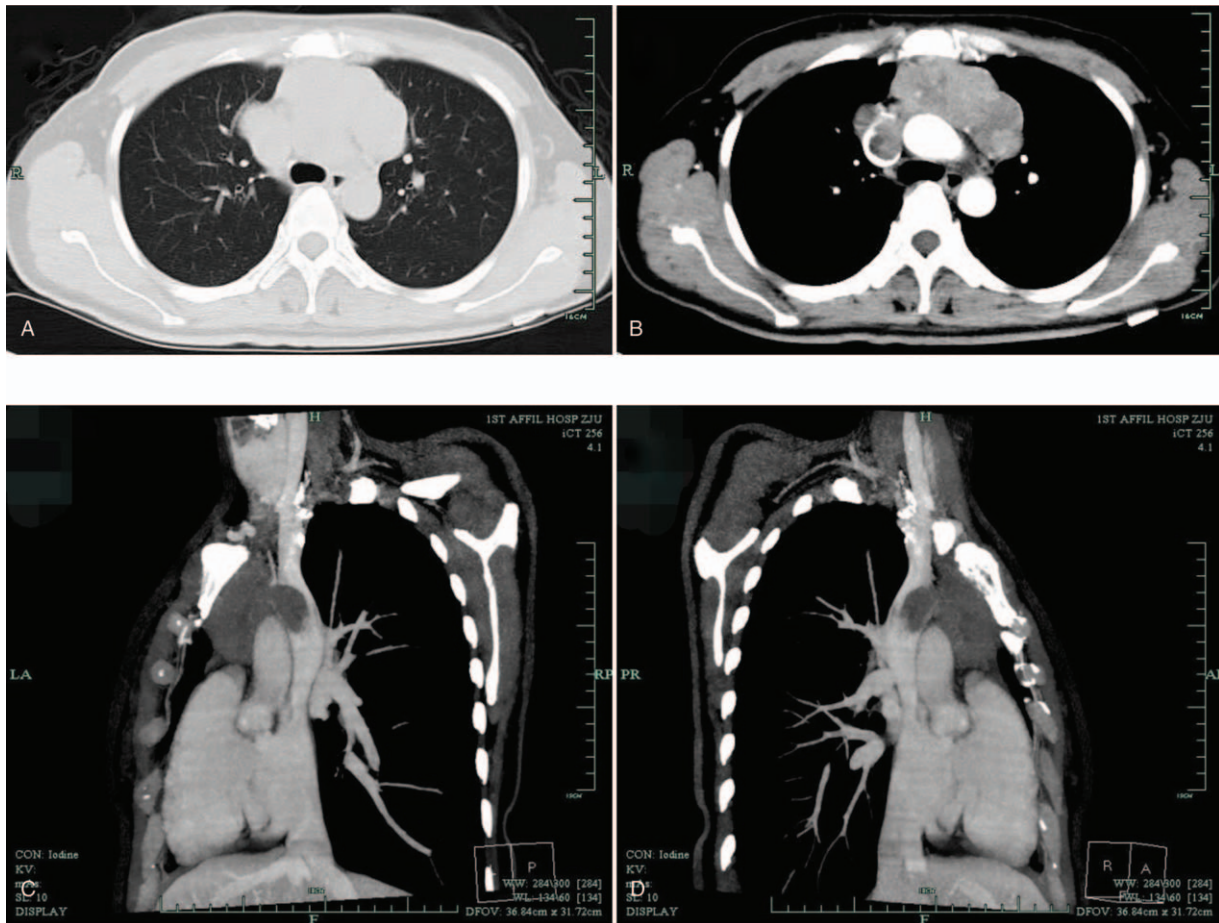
Image examination before operation. (A and B) Contrast computer tomography of the tumor before surgery. (C and D) Computer tomography angiography (CTA) showed tumor thrombus in superior vena cava and left brachiocephalic vein.
